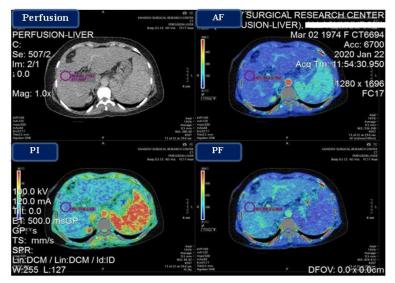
CT perfusion in hepatic fibrosis.
